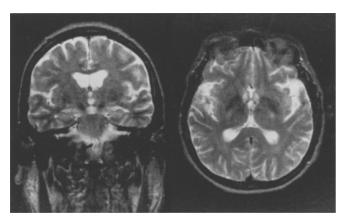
The MRI scan, T₂-weighted (TR 2.0; TE 90), shows mild atrophy without circumscribed lesions
